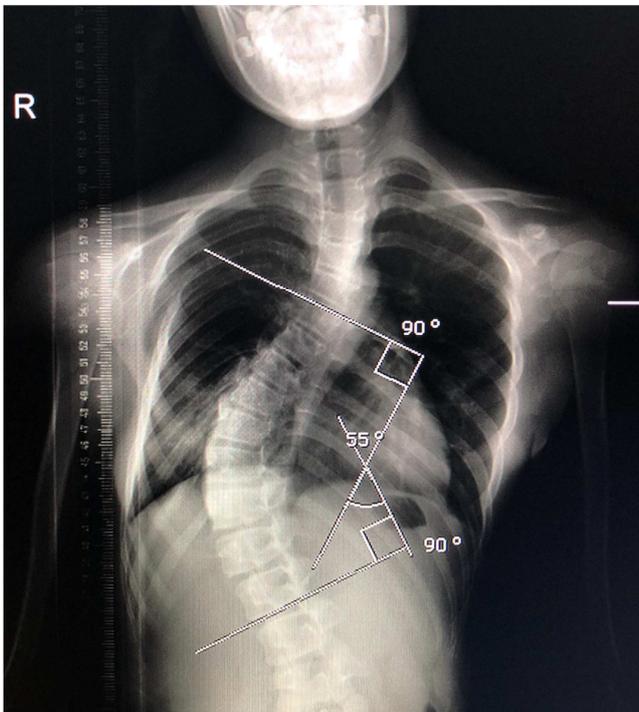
Chest Radiography with the Cobb's Angle Measurement of the Case.
